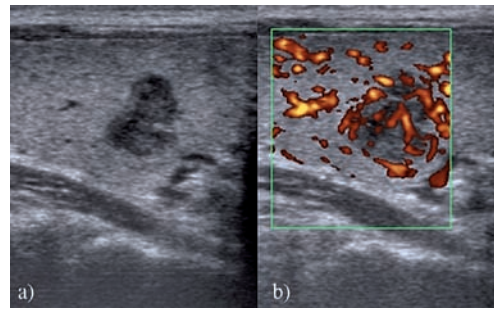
A 48 years old man with papillary carcinoma of the thyroid. a) longitudinal sonogram of the right lobe of thyroid shows an irregular contoured, hypoechoic and taller than wide shaped nodule. The size of the nodule on its maximal dimension is under one centimeter. b) power Doppler US (longitudinal view) shows extensive intranodular vascularity.
